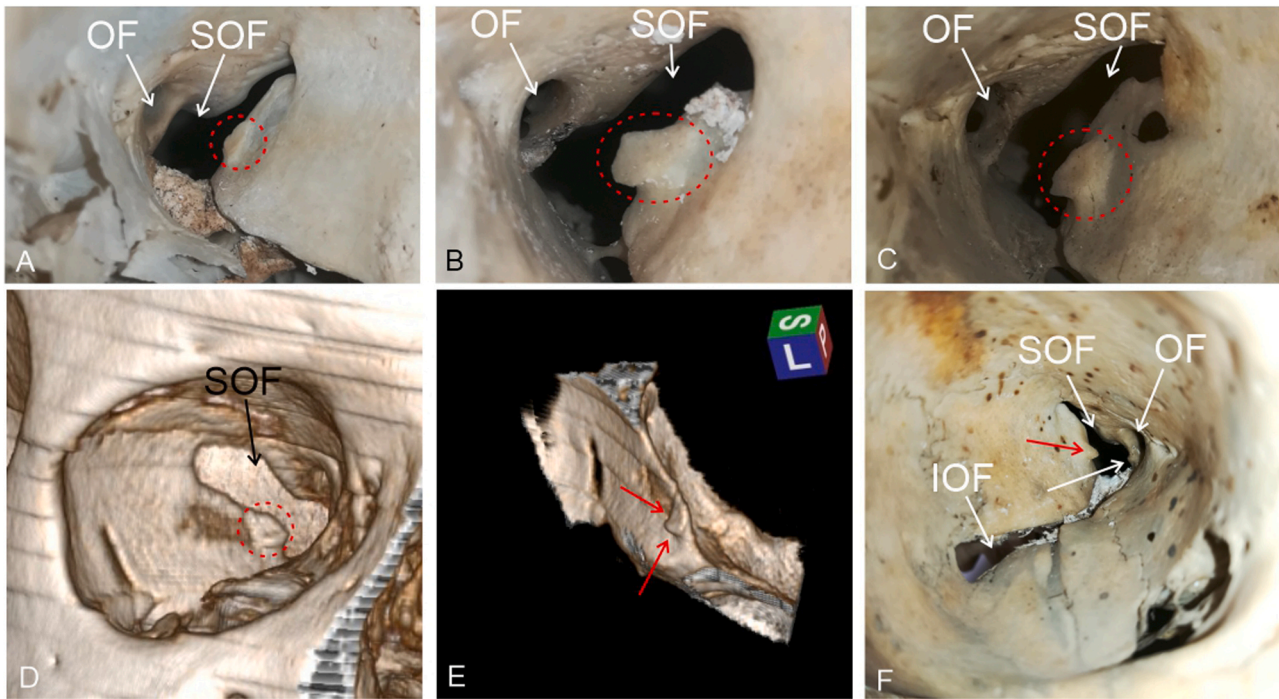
Morphologic variation of the plaques; tubercles on the optic strut opposite to the SMRL. OF = Optic foramen; SOF = superior orbital fissure; IOF = inferior orbital fissure A) Small plaque (within the red framed area) placed just in front of the SOF; B) Quadrangular large plaque (within the red framed area) projects for several millimeters into the orbit; C) Plaque shaped like an SMRL with clear step-like boundaries (within the red framed area). It projects for several millimeters into the orbit; D) 3D-rendering of a CT scan with a plaque (within the red framed area) very similar to example in C; E) The same plaque in D as seen after clipping away most of the skull and leaving the orbital plate of the sphenoid. The oblique view from above, medially and behind gives a better appreciation of the step-like boundaries of the plaque (red arrows); F) An SMRL (red arrow) is associated with a small tubercle raising from the base of the optic strut (white unlabeled arrow).
